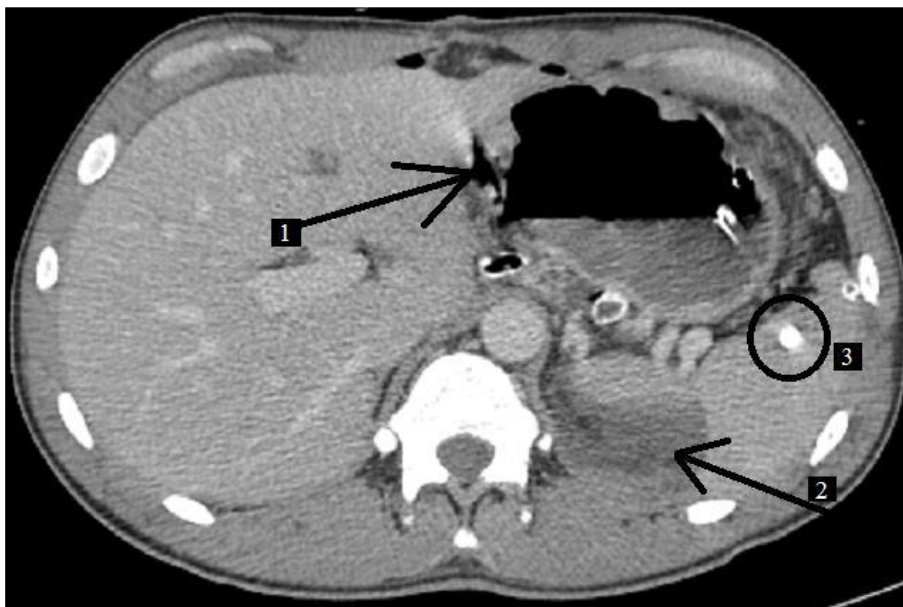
CT scan of abdominal organs, axial projection. Free gas (1) and fluid (2) in the abdominal cavity in the case of a penetrating gunshot wound to the abdomen, the foreign body (bullet) (3) is in the spleen.
